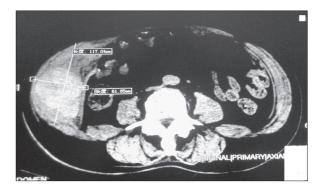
Contrast-enhanced CT of the abdomen showing a huge hematoma in the right lateral abdominal wall.
